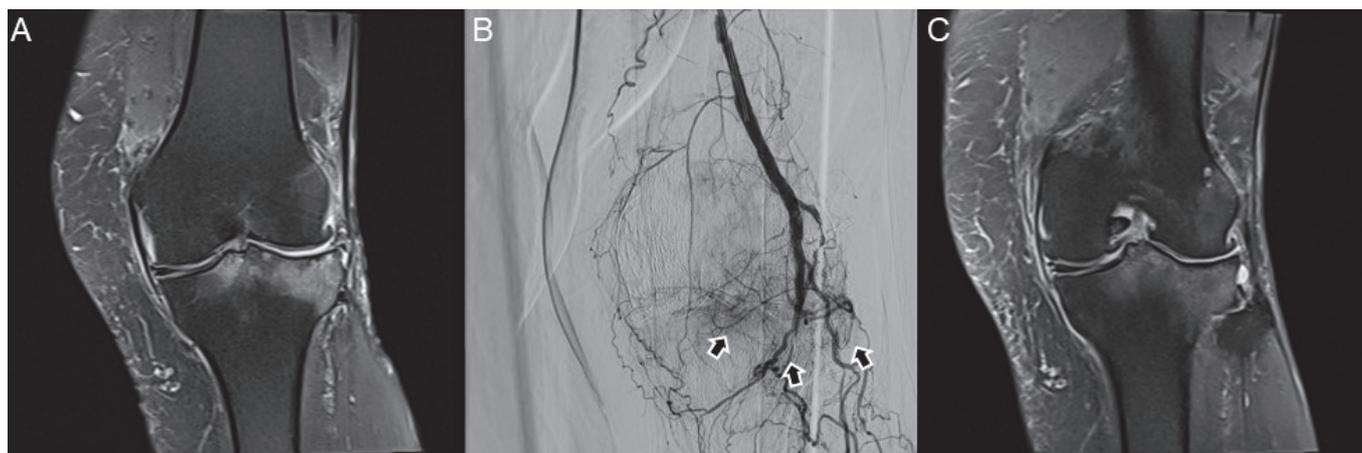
Magnetic resonance imaging and angiographic findings in an 87-year-old patient affected by osteoarthritis. The patient had undergone multiple conventional therapies over the years, including joint infiltrations and oral analgesics. She was not considered a candidate for TKA due to high surgical risk. Coronal fat-saturated T2-weighted MRI (A) shows diffuse oedema in the lateral compartment of the tibia. DSA performed at the femoral-popliteal transition (B) shows an area of hypervascularisation (blush) in the lateral compartment of the tibia (arrows) corresponding to the MRI finding. Magnetic resonance imaging conducted 4 months post embolization (C) exhibits a notable attenuation of bone marrow oedema; clinically, the patient reported diminished symptomatic pain and achieved unaided ambulation.
